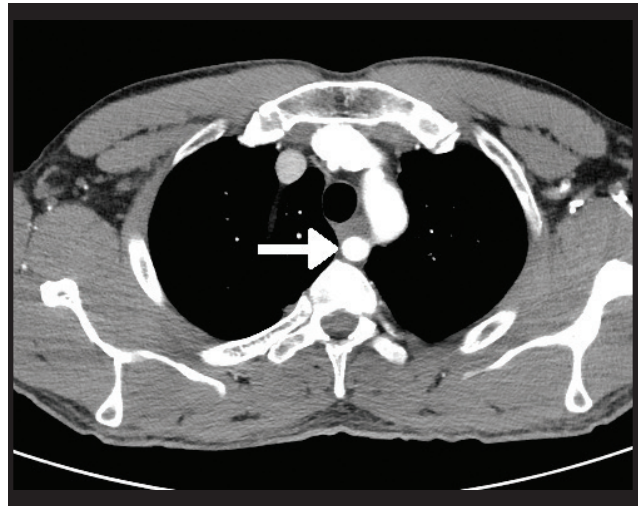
Computed tomography chest: demonstrates an aberrant, right subclavian artery (arrow) coursing posteriorly to the esophagus, causing mild compression of such structure. No aneurysm of the subclavian artery can be appreciated, with the remainder of the mediastinum being unremarkable.
